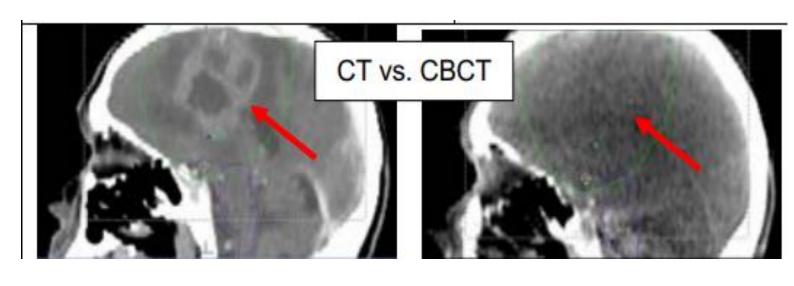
CT (left) and CBCT (right) images of a brain tumor, which is clearly visualized in CT but hardly seen in CBCT (UNC data).
